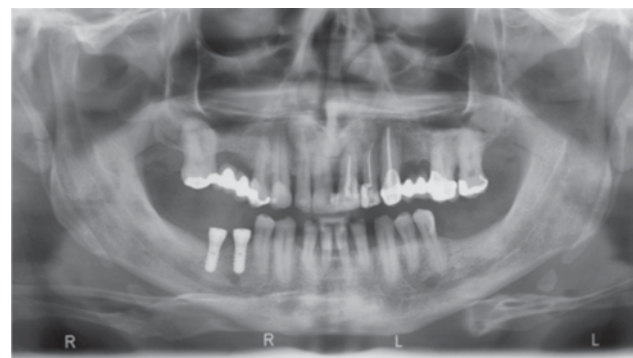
Pretreatment panoramic radiograph demonstrating severe destruction of the alveolar bone in the maxillary left central incisor
